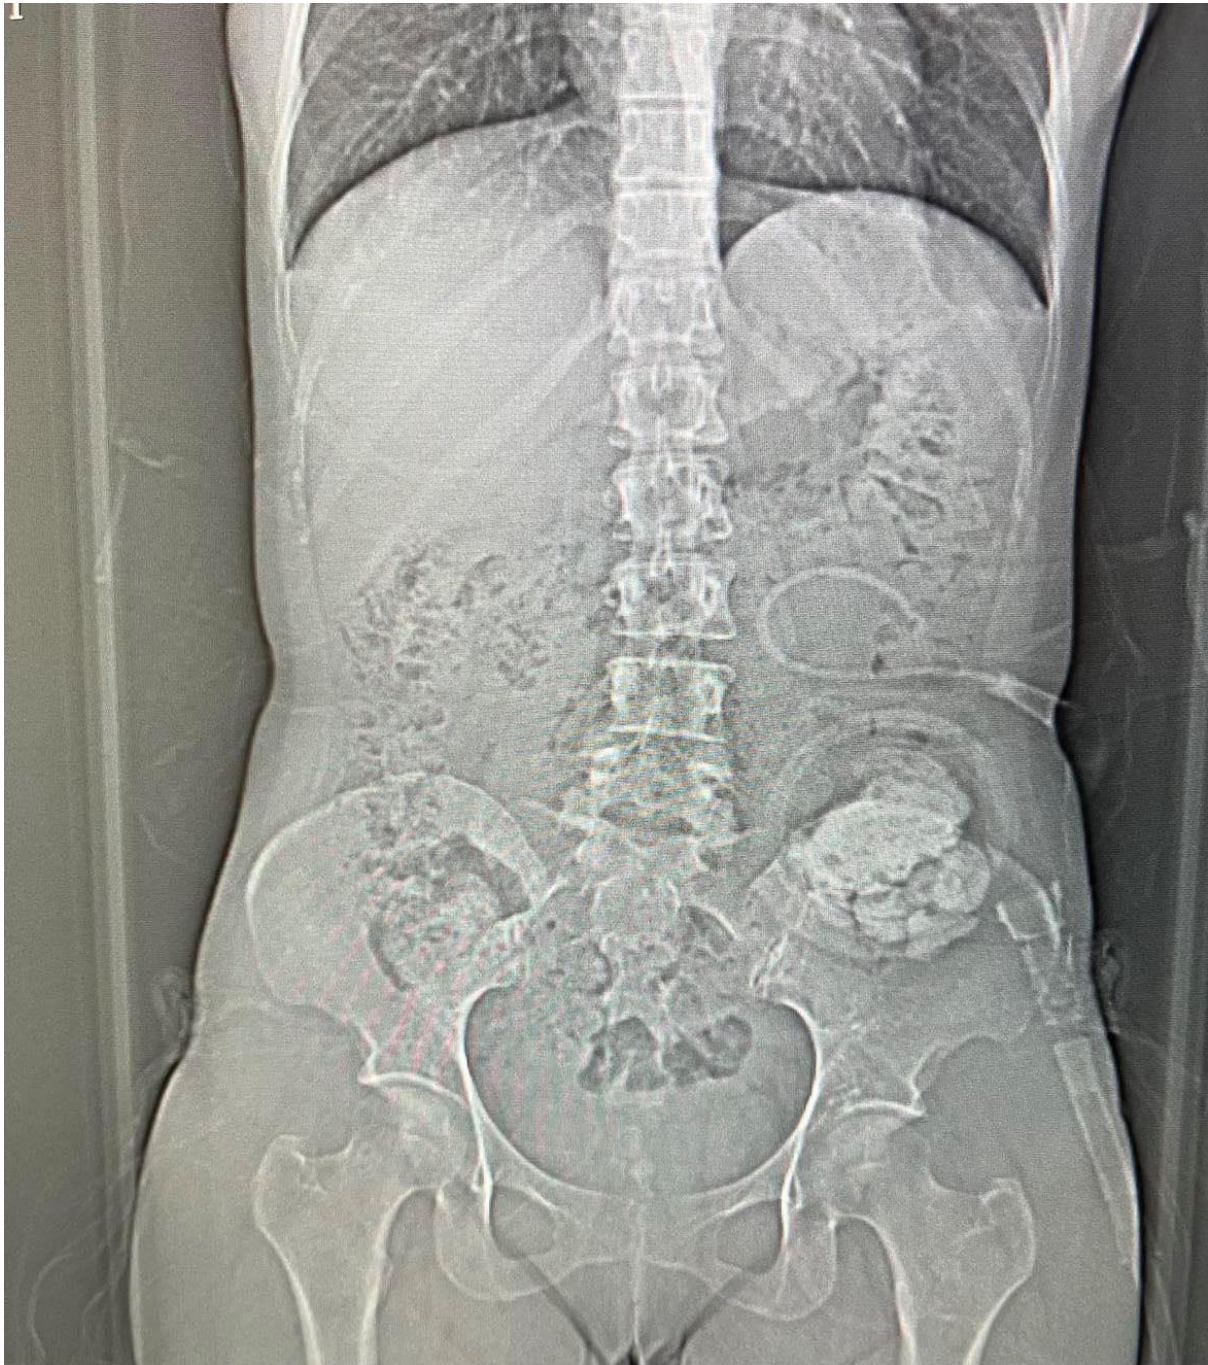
CT scan with visible Nelaton catheter within the left kidney.
